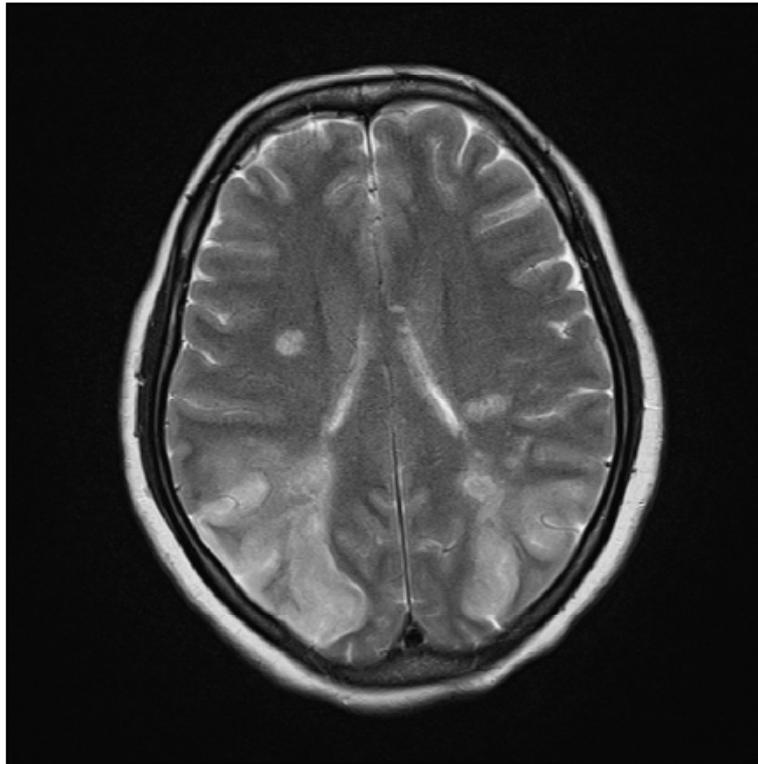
T2 WI MRI images demonstrating symmetric hyperintensities in bilateral parietal and occipital lobes; characteristic of Reversible Posterior leukoencephalopathy syndrome.
